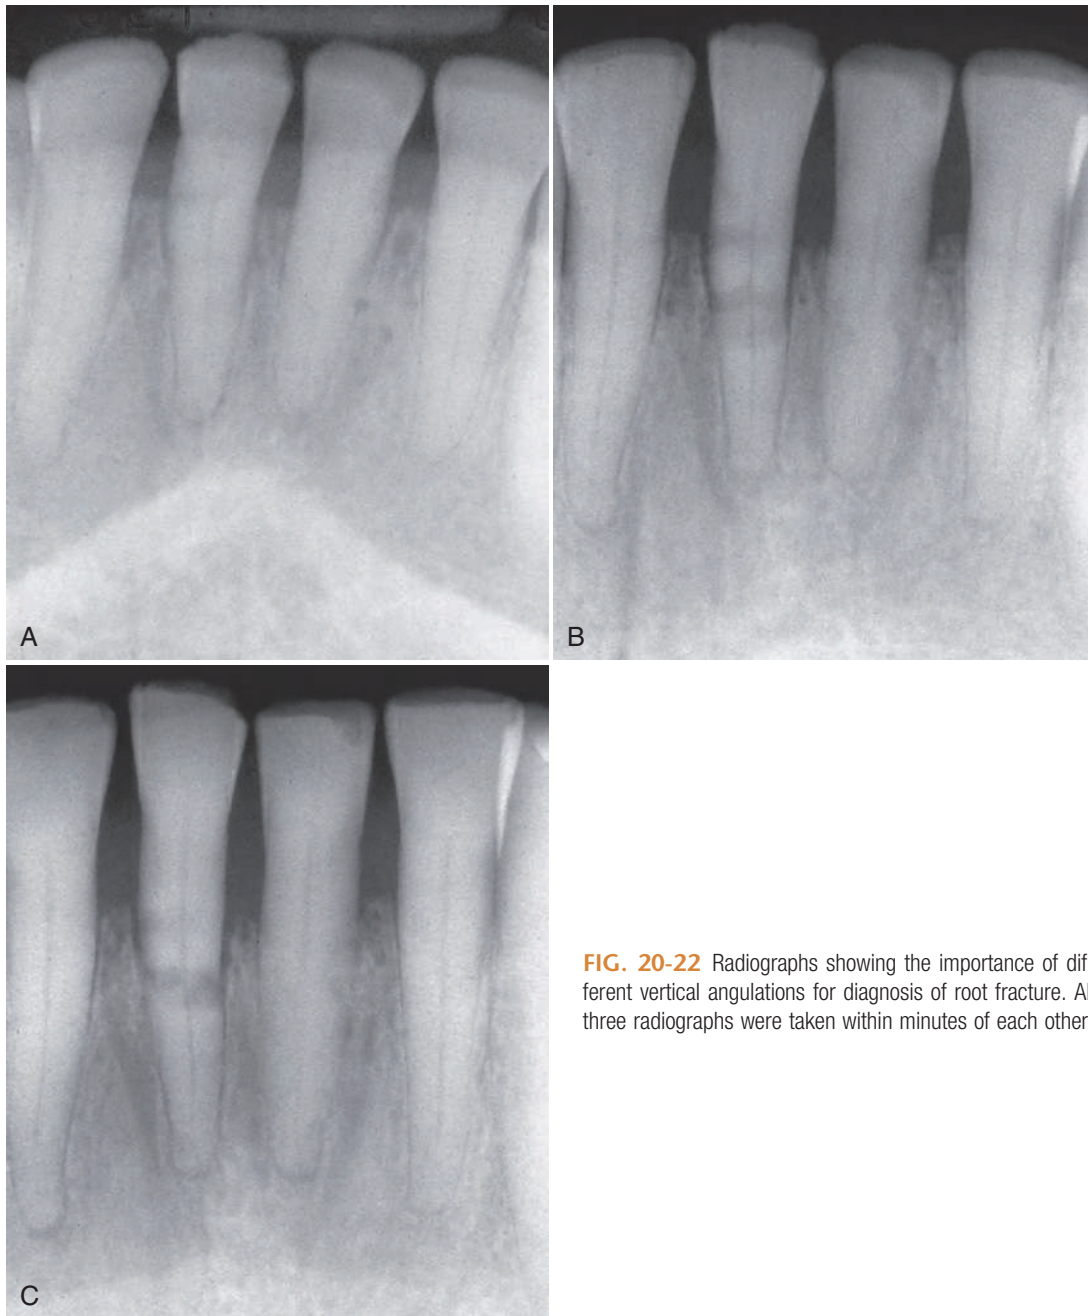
Radiographs showing the importance of different vertical angulations for diagnosis of root fracture. All three radiographs were taken within minutes of each other.
